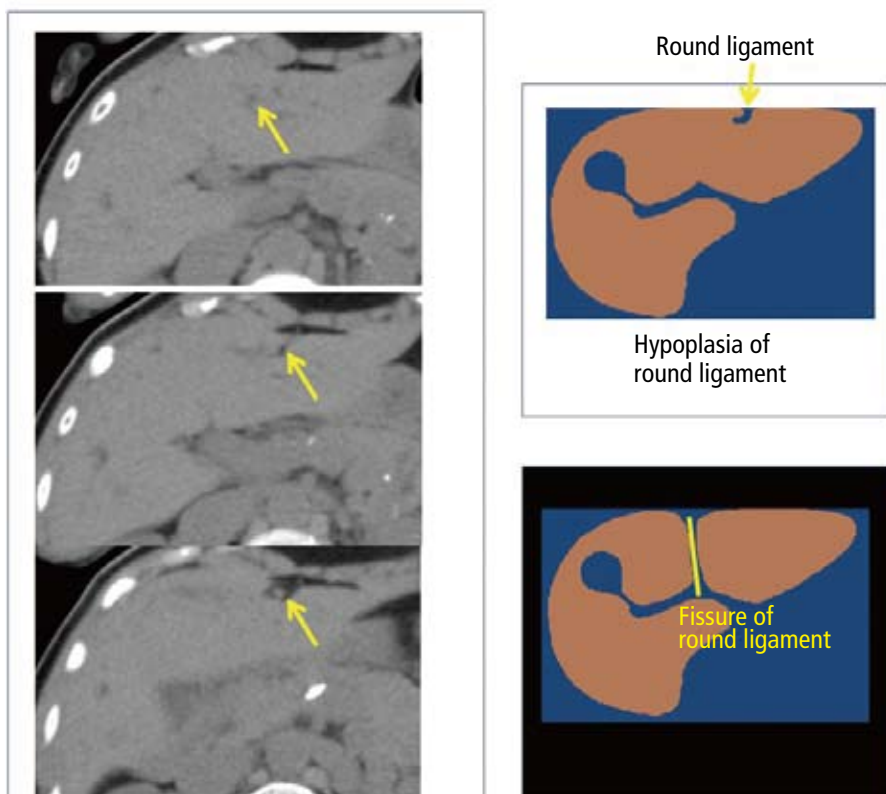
Lobulation defect of the superior and inferior lateral segments of the left lobe of the liver. Axial image of unenhanced CT. The barely visible fissure of round ligament indicates hypoplasia (arrow).
